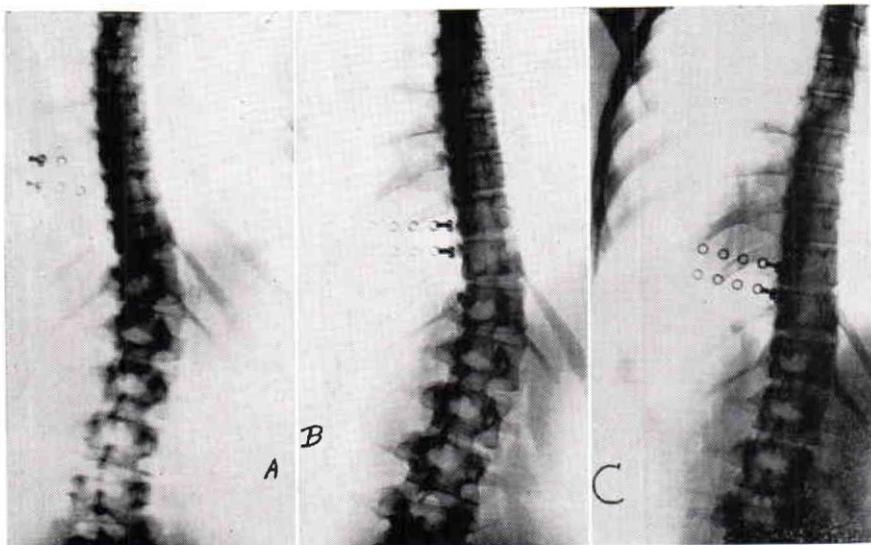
X-rays of a post-polio scoliotic spine, age fifteen
